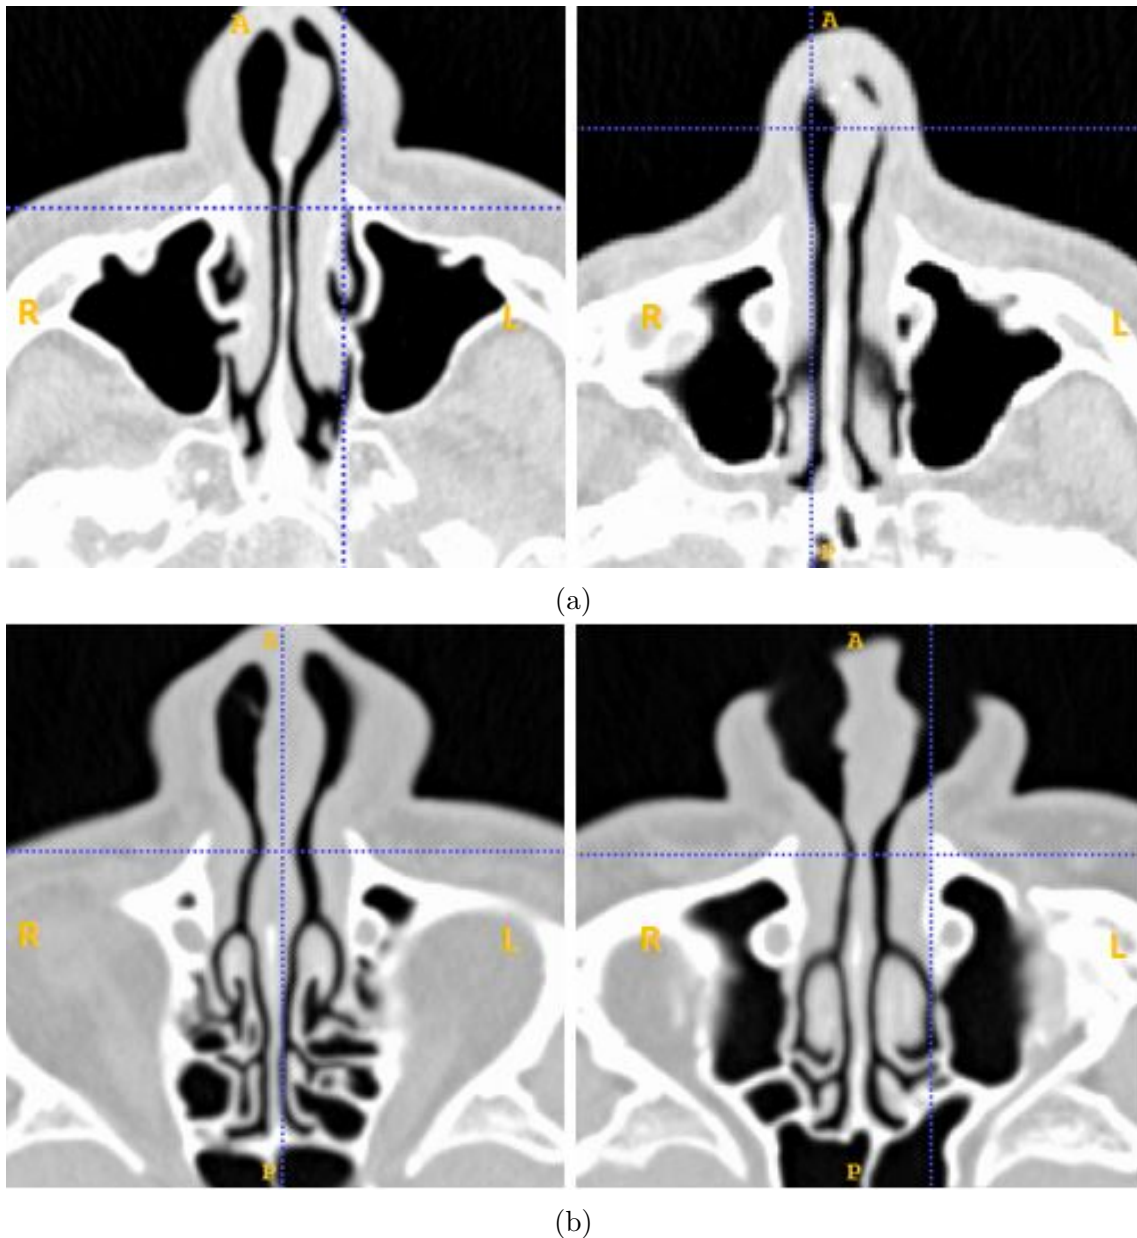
The figure shows two different CT axial views of Patient 12 taken pre-operative. No remarkable difference in the cross-sectional areas of the left- and right nasal cavity in the middle of the nose are observed.
